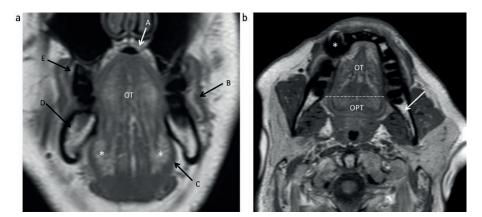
Normal MRI anatomy of the oral cavity: (a) coronal and (b) axial T1-weighted images of the oral cavity. (a) Shows paired sublingual glands (*) in the sublingual spaces; (b) shows dental amalgam artefact (*) obscuring some local detail. The oropharyngeal tongue (OPT) is the posterior one third of the tongue behind the plane of the circumvallate papillae (not seen on MRI and approximated by dashed line). OT = oral tongue, OPT = oropharyngeal tongue, A = hard palate, B = buccinator muscle, C = mylohyoid muscle, D = mandibular alveolar bone, E = maxillary alveolar bone
